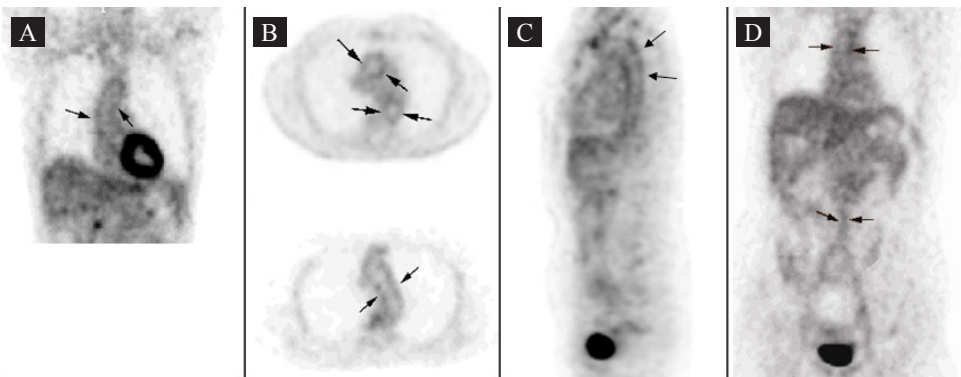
¹⁸F-FDG uptake in the ascending aorta, arch of aorta, descending thoracic and abdominal segments of the aorta (arrows) on coronal (A, E), axial (B, C), and sagittal (D) slices. Mean SUV were calculated using axial slices (B, C).
